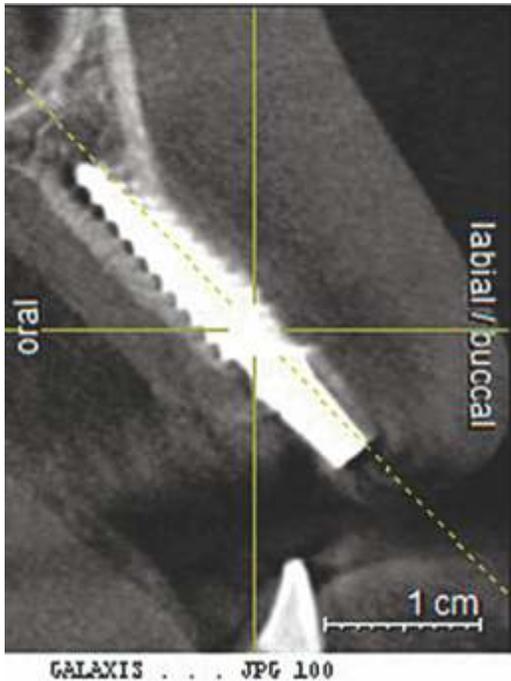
Post op CBCT [Lt]
